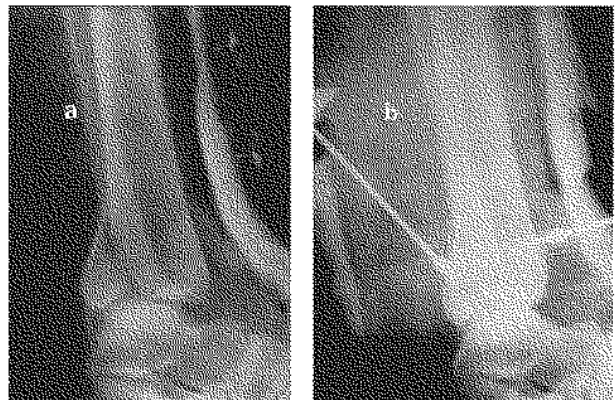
Lateral radiographs showing a trimalleolar fracture (SE stage IV) with third malleolus involving more than 25% of the articular surface. a) Unsatisfactory closed reduction of third malleolus. b) Very satisfactory reduction after application of two Delitala pressers.
